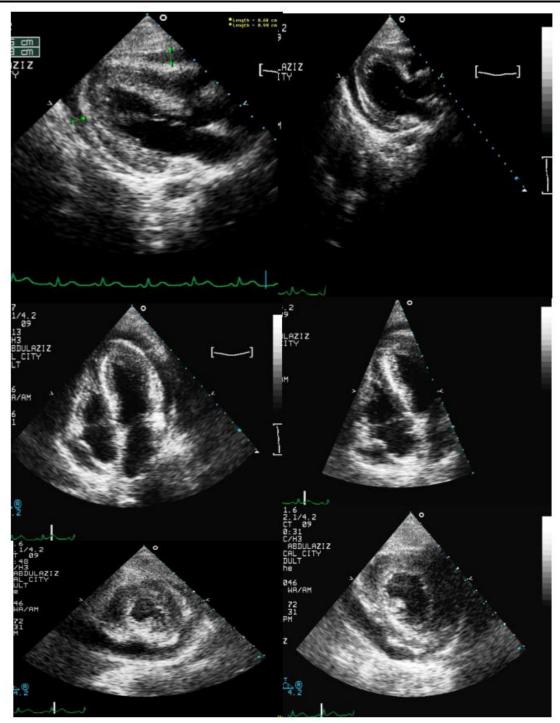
Echocardiogram demonstrating moderate concentric left ventricular hypertrophy (myocardial edema manifested by increased wall thickness); left ventricular systolic function is moderate to severely reduce; ejection fraction is 25%–35%; moderate to severe global hypokinesis of the left ventricle; and moderately sized pericardial effusion, with early signs of cardiac tamponade. The right ventricle is normal in size and function, with normal function and structure of the valves
